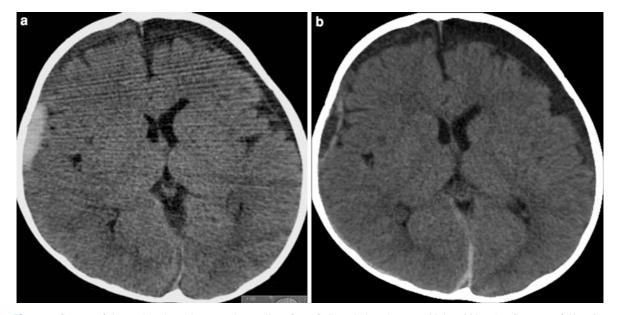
Influence of decreasing the voltage on the quality of a brain CT in a 1-year-old child with subdural hematomas of variable age. a Scan at 120 kV, 250 mAs, CTDI_{Vol} of 45 mGy, DLP of 688 mGy cm, estimated effective dose of 4.8 mSv.
